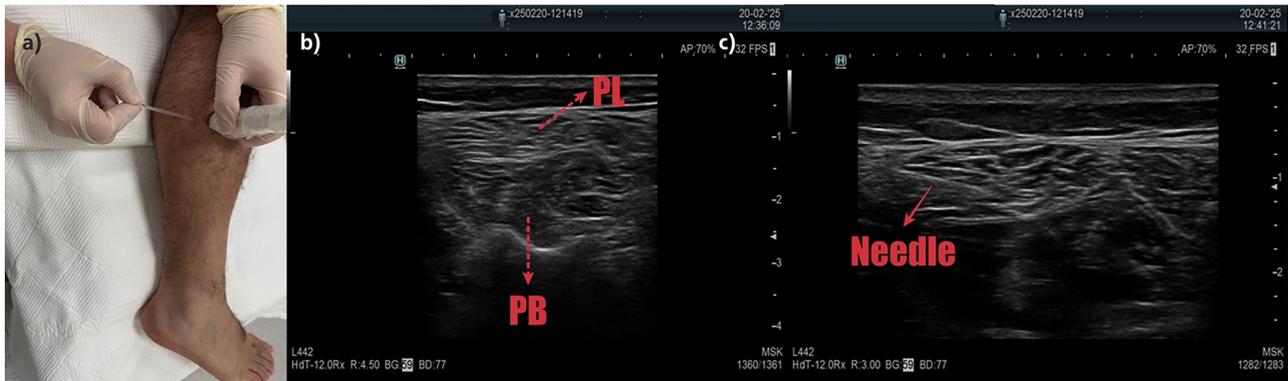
a) Patient positioned in a side-lying position with the treated leg on top, allowing optimal access to the peroneal muscles, b) Ultrasound image of the peroneal muscle anatomy. The peroneus longus (PL) is located more superficially, while the peroneus brevis (PB) is positioned deeper. Real-time visualization aids in identifying myofascial trigger points and fascial restrictions, c) Needle placement under ultrasound guidance. The needle is directed precisely into the (PL) muscle, allowing for accurate targeting of myofascial trigger points while minimizing the risk of injury to adjacent structures
